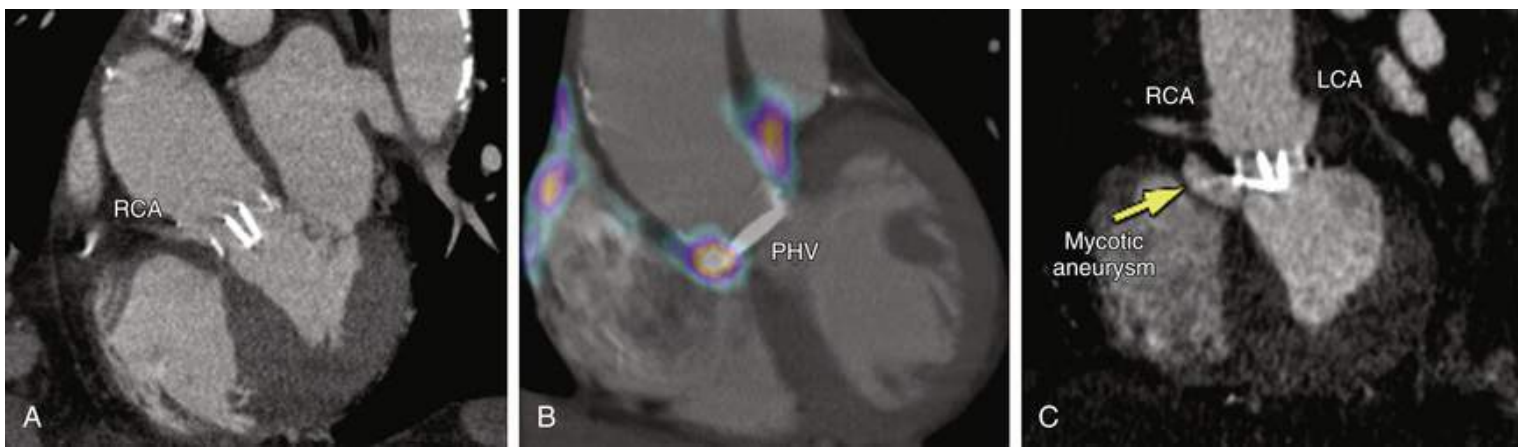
Periannular prosthetic valve endocarditis detected by FDG PET. Patient with bileaflet mechanical aortic prosthetic heart valve (PHV), placed 20 years earlier, presented with fever and blood cultures positive for *Staphylococcus aureus*. Despite a high degree of clinical suspicion for endocarditis, findings on transthoracic echocardiography and TEE, as well as CT (A), were unremarkable for evidence of infection. B, FDG PET–low-dose CT fused image revealed high uptake around aortic PHV (*arrows*), near the proximal right coronary artery (RCA). C, Subsequently, CT revealed a mycotic aneurysm beneath the RCA origin, confirmed by urgent operation. In this case, only FDG PET–CT detected these abnormalities at a very early stage. LCA, Left coronary artery. (A, B, Modified from Tanis W, Scholtens A, Habets J, et al. Fusion of cardiac computed tomography angiography and ^{18}F -fluorodesoxyglucose positron emission tomography for the detection of prosthetic heart valve endocarditis. *J Am Coll Cardiol Imaging* 2013;6:1008.)
